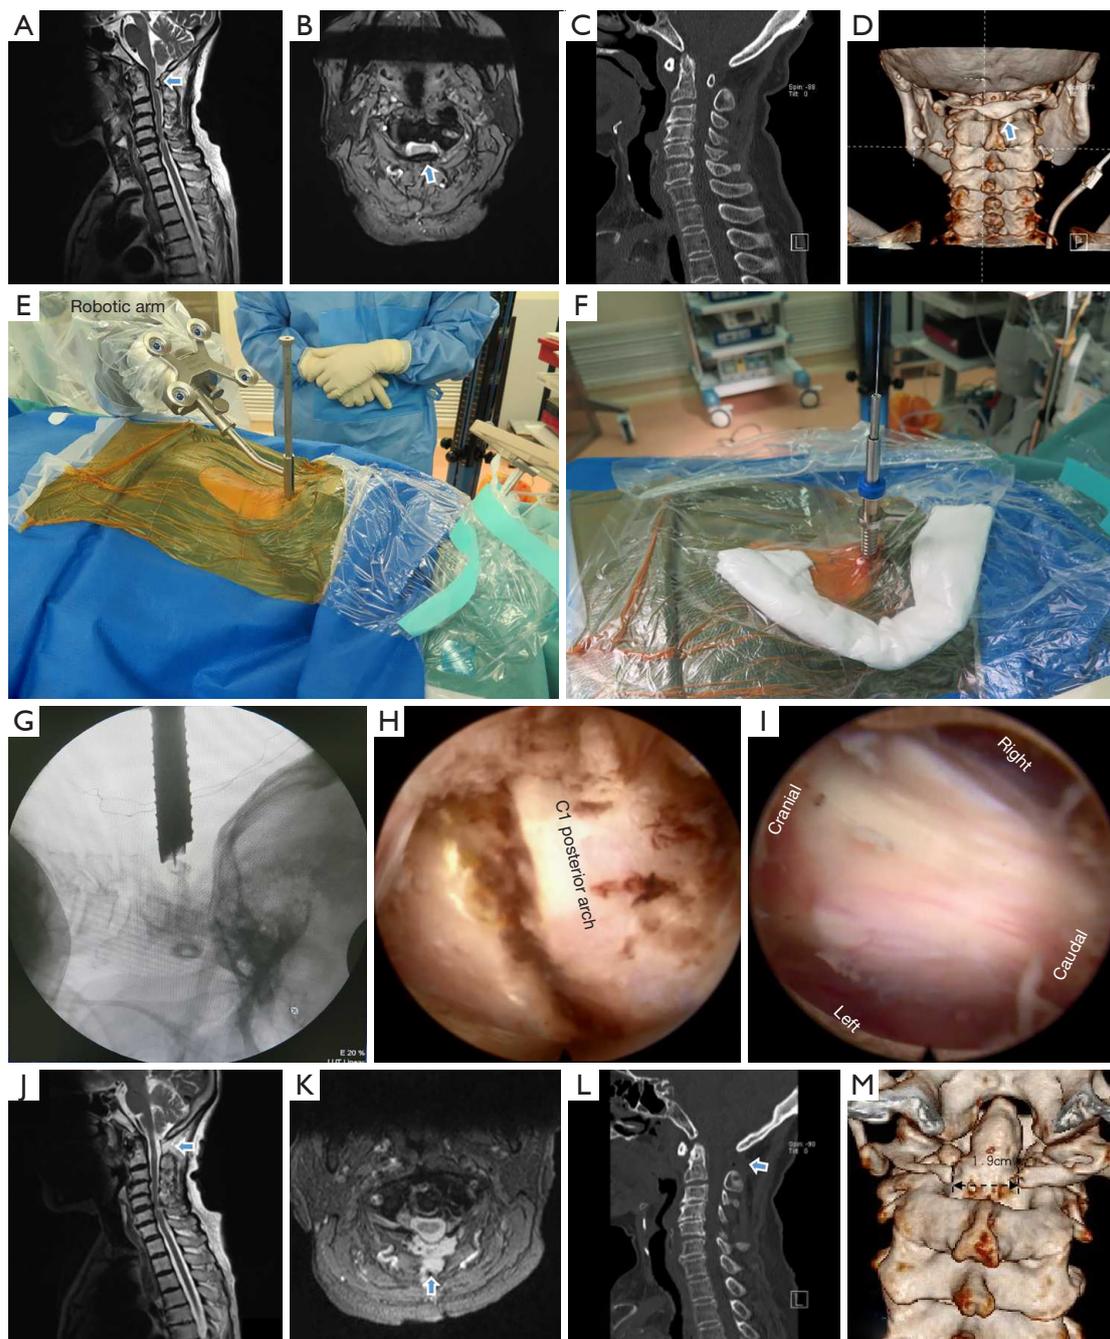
An 83-year-old female with DASM and C5–6 CSM who underwent PFEC1L and percutaneous full endoscopic C5–6 decompression. (A) Preoperative sagittal T2-weighted MRI. The arrow indicated the obvious compression of the spinal cord at the level of C1 and C5–6. (B) Preoperative axial T2-weighted MRI. The arrow indicated the malformations of the PAA had compressed the spinal cord. (C) Preoperative sagittal CT scan, the SAC was 7.0-mm. (D) Preoperative three-dimensional CT. The arrow indicated the abnormal left-right asymmetry of the PAA. (E–G) The creation of an appropriate endoscopic surgical corridor with robotic assistance. (H) The PAA under the endoscopic view. (I) No sign of spinal cord compression after PFEC1L. (J,K) Postoperative MRI. The arrow indicated the spinal cord compression was relieved, especially at the level of the atlas. (L,M) Postoperative CT scan. The arrow indicated that the PAA was removed. DASM, developmental atlantal stenosis with myelopathy; CSM, cervical spondylotic myelopathy; PFEC1L, percutaneous full endoscopic C1 laminectomy; MRI, magnetic resonance imaging; PAA, posterior arch of the atlas; CT, computed tomography; SAC, space available for the cord; PAA, posterior arch of the atlas.
